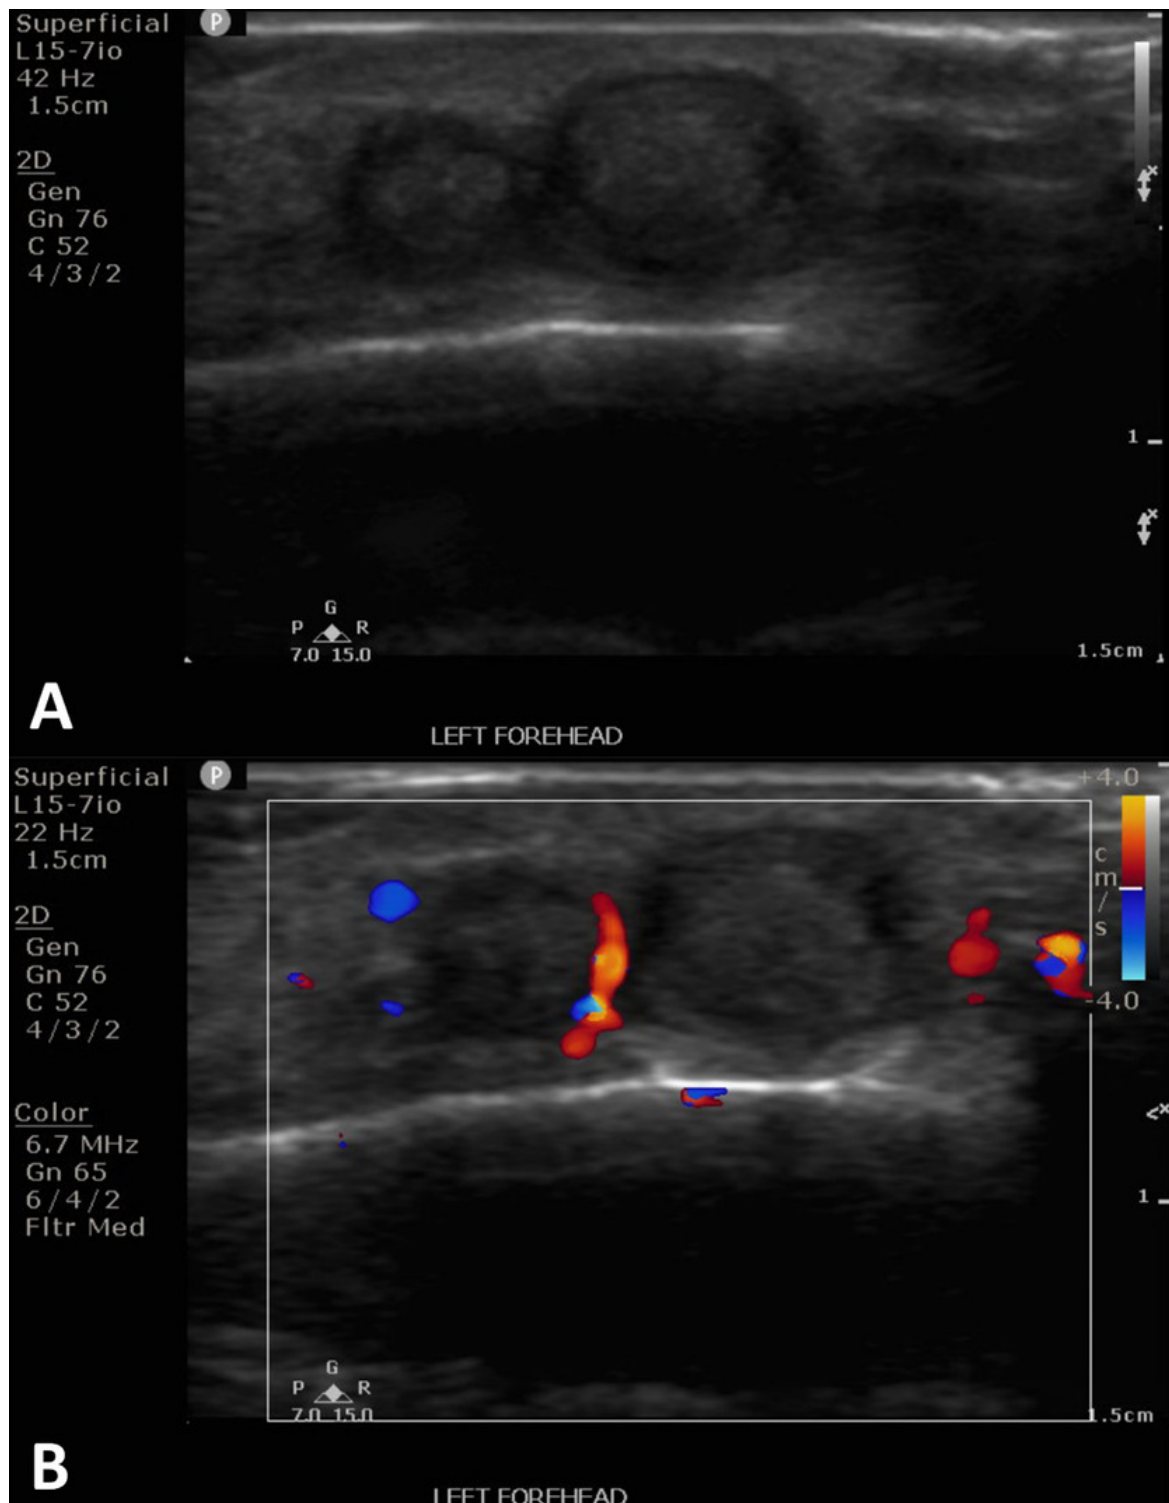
Post Intervention Ultrasound. A: Grayscale Ultrasound demonstrates new presence of internal echogenicity within the tandem pseudoaneurysms consistent with thrombotic material. B: Further confirmation of pseudoaneurysm thrombosis is shown as absence of color flow within the pseudoaneurysms on arterial duplex.
